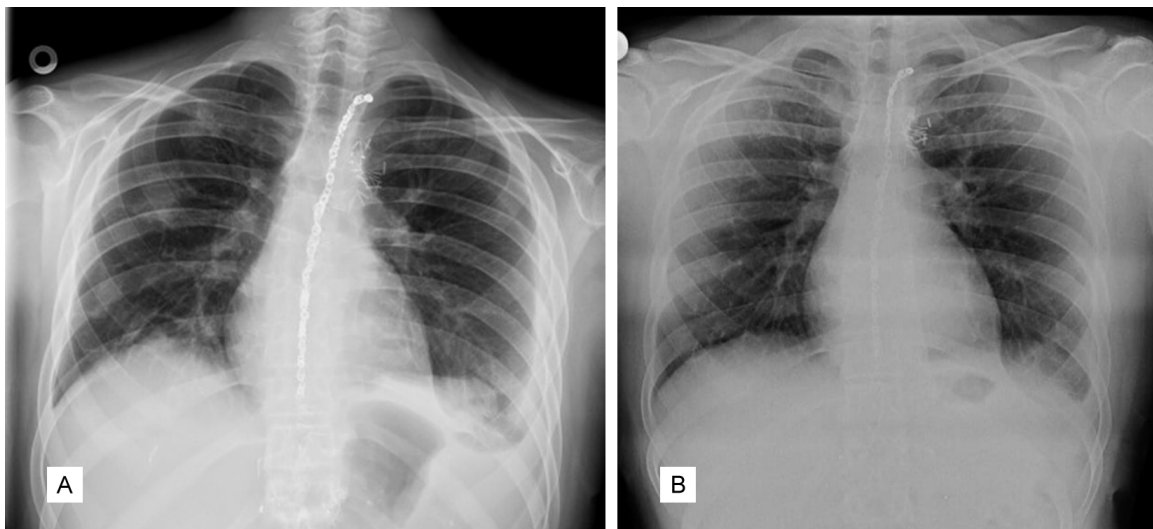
A PA chest radiograph on the day of discharge (A) shows metallic densities secondary to coils in the mediastinum and substantially decreased pleural effusion in the left hemithorax. The chest radiograph (B) taken 14 months later was normal except for metallic densities from the coils and surgical clips and blunting in the left costophrenic sinus which is a sequela of chylothorax.
